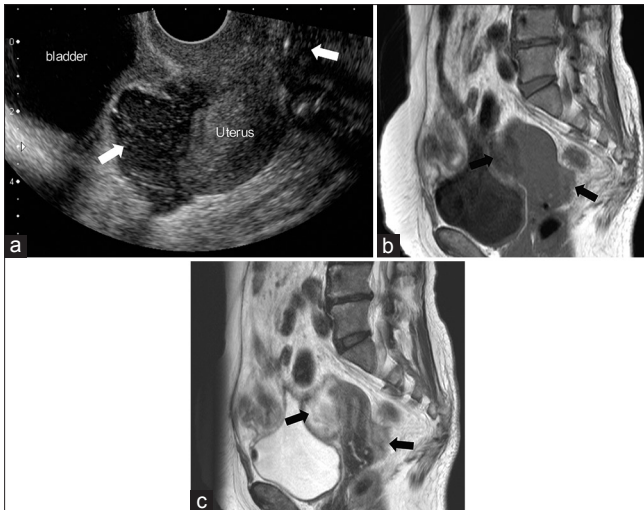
(a) Ultrasound image showed abscess of vesicouterine pouch and the Douglas' pouch (white arrow). (b) Axial T1-weighted magnetic resonance imaging showed abscess of vesicouterine pouch and the Douglas' pouch (black arrows). (c) Axial T2-weighted magnetic resonance imaging showed abscess of vesicouterine pouch and the Douglas' pouch (black arrows)
